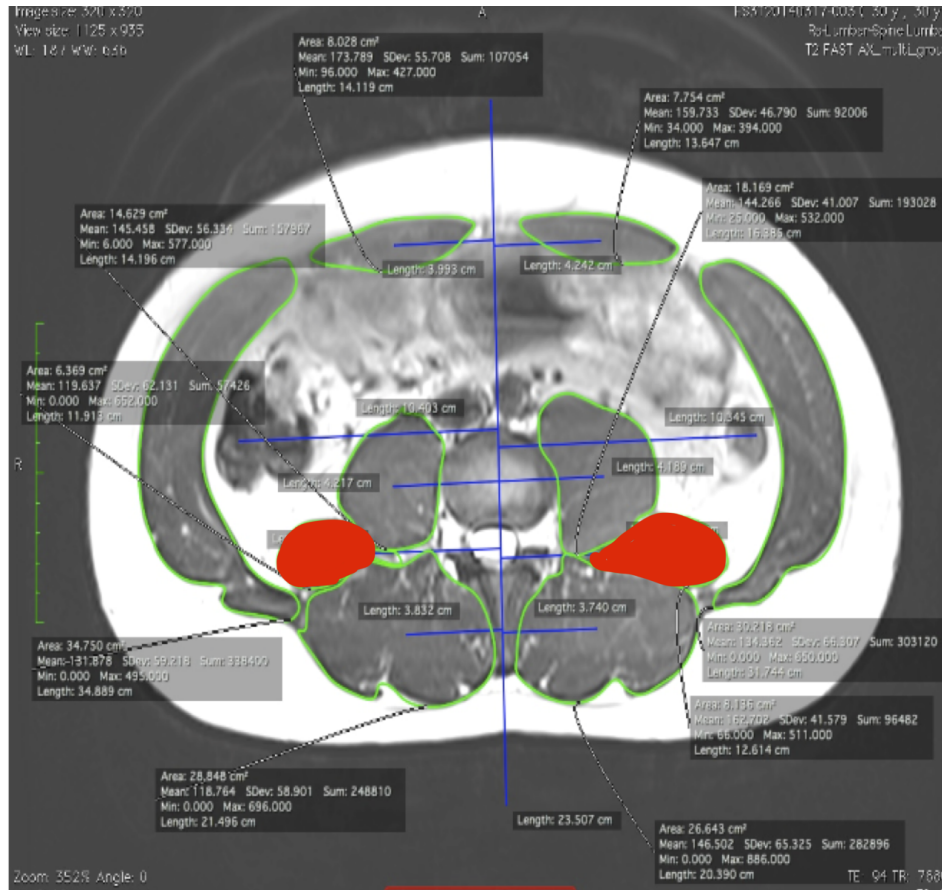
MRI Axial View of the QL Muscles
